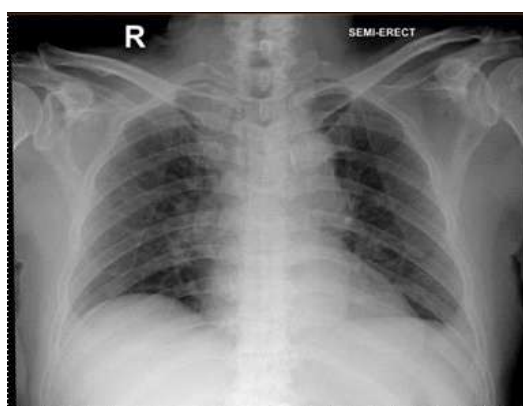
Thorax Plain Radiography from the patient
